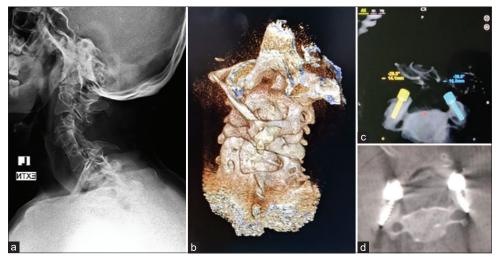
Preoperative radiographs (a) and computed tomography (b) of a patient with Klippel Feil syndrome with previous cervical laminectomy showing significantly altered anatomy. Screenshot of robotic workstation showing planning of lateral mass screw in the presence of altered anatomy (c). Postoperative computed tomographic scan showing well placed lateral mass screw (d)
